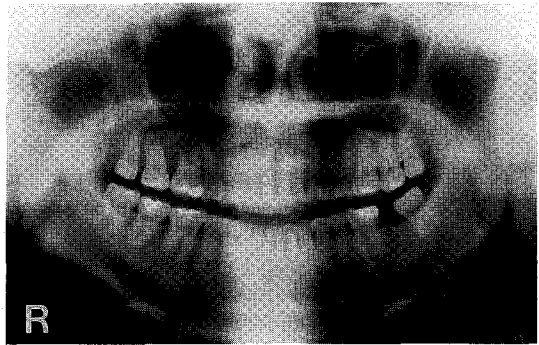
Panoramic Radiograph. It shows the periapical osteolytic lesion at the right maxillary area (#13-18) with root resorption of the first and second molar teeth.
